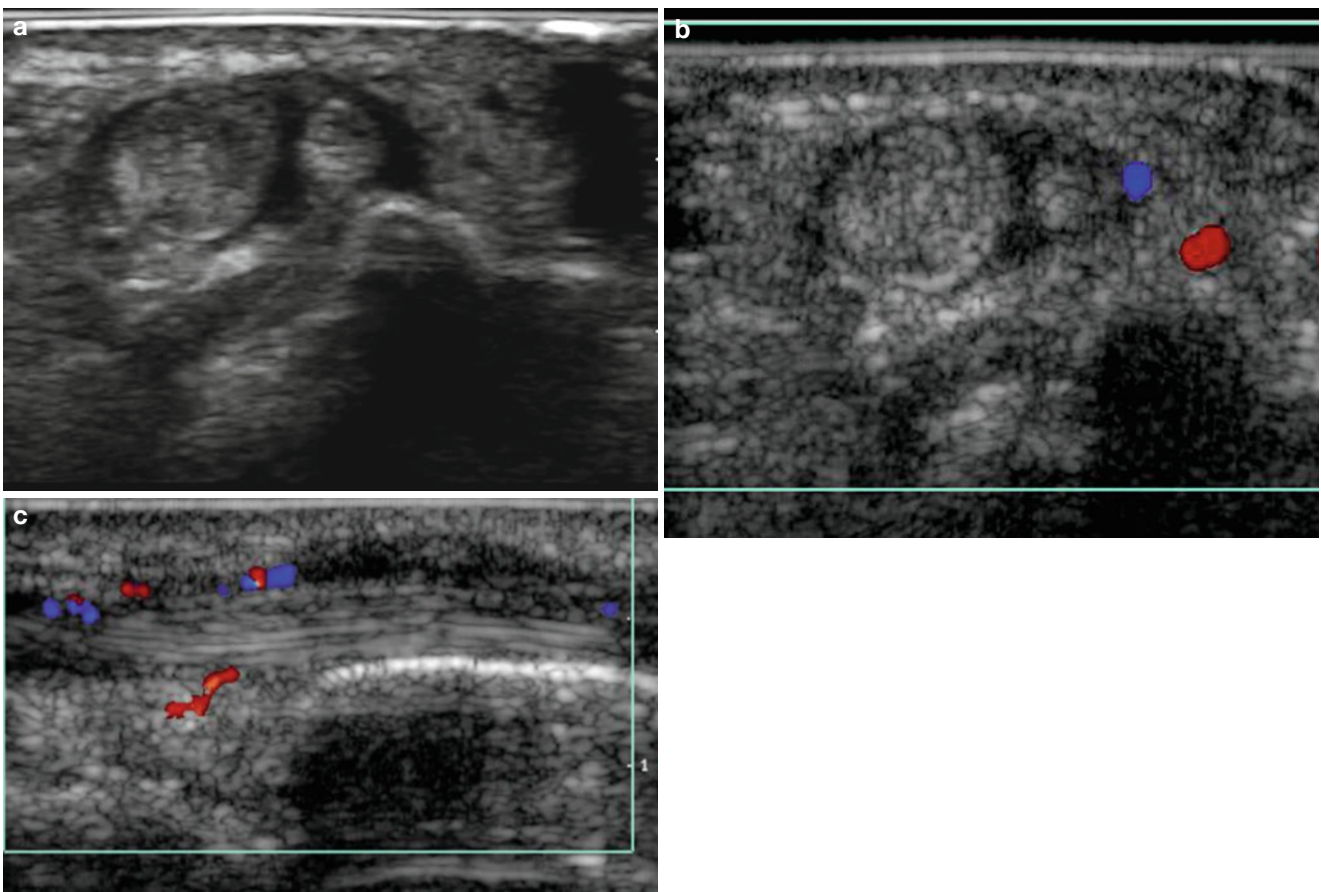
(a–c) Quervain’s tenosynovitis. (a) Grey scale ultrasound image (transverse view, right wrist) shows thickening of the abductor pollicis longus and extensor pollicis brevis tendons and their synovial
